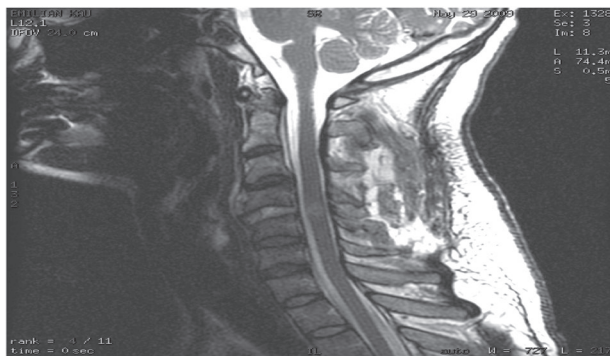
MRI after the surgical approach.
